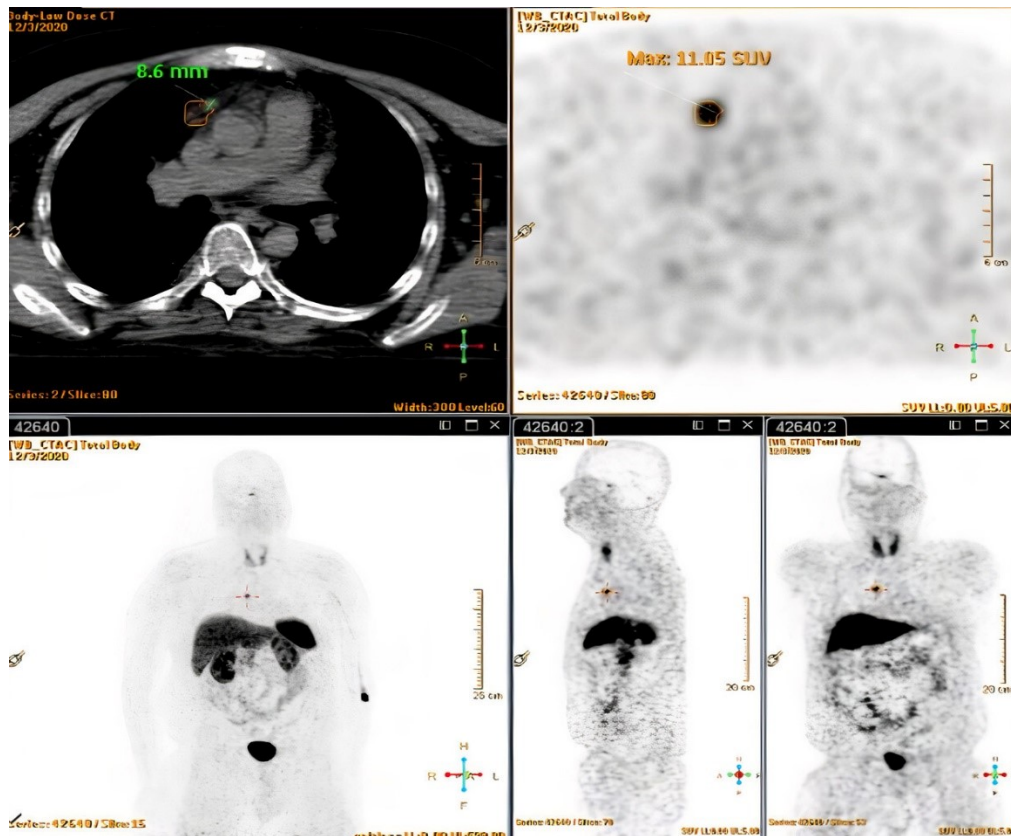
⁶⁸Ga-DOTANOC PET/CT. A single uptake focus (max SUV = 11) on the right mediastinum corresponding to a pericentimetric nodule localized on pericardial fat.
